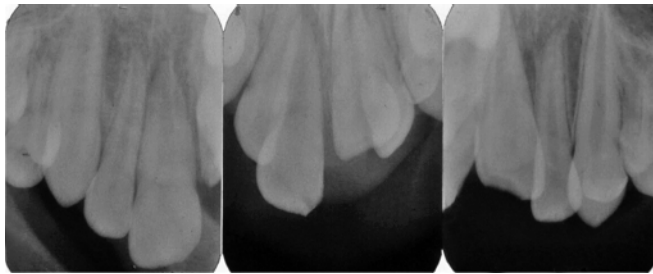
Radiograph showing intrusive luxation injury
